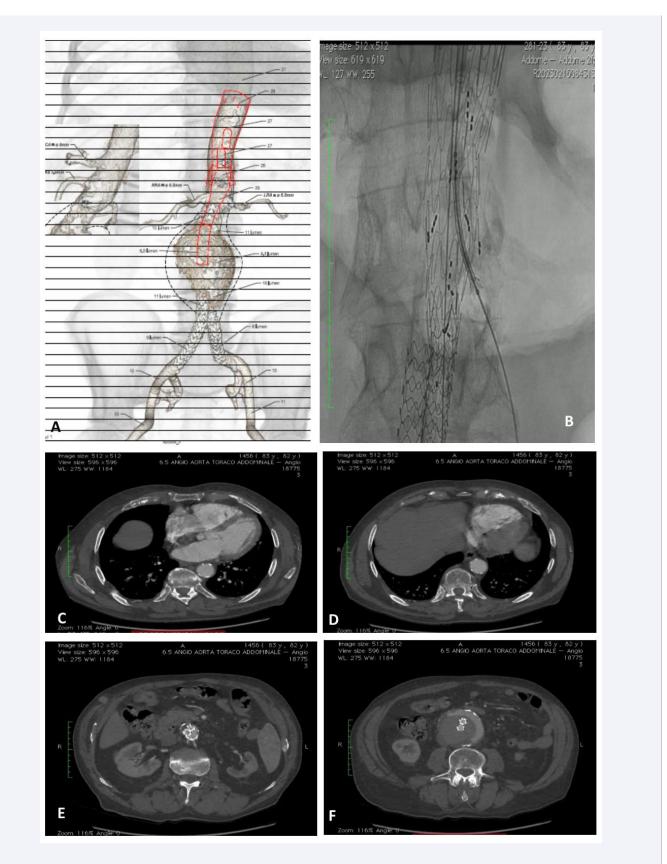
(A) (B) Preoperative CT image demonstrating a voluminous infrarenal abdominal aortic aneurysm with a transverse diameter of 82mm; (C, D, E, F) persistent type Ia endoleak in different CT image views.
